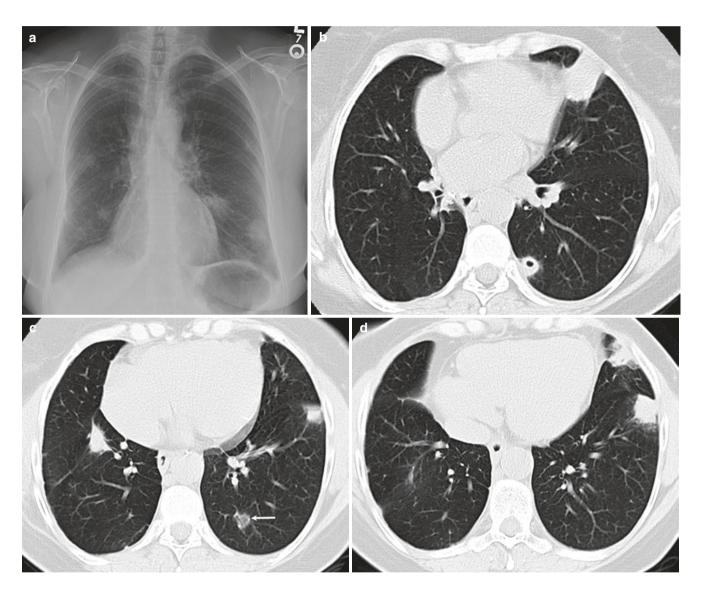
A 5 3-year-old woman with granulomatosis with polyangiitis. (a) Frontal radiograph shows multiple ill-defined peripheral nodules. (b-d) Axial CT images show multiple cavitary nodules and nodules with reverse halo sign and halo sign
